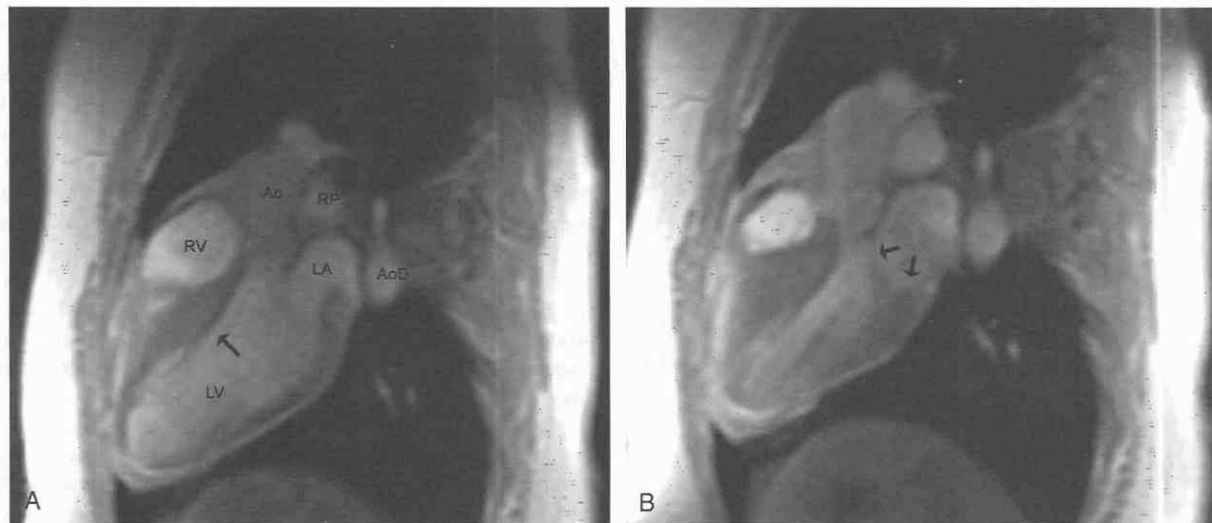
MR image obtained from a 17-year-old girl with hypertrophic obstructive cardiomyopathy. *A*, End-diastolic (ED) oblique axial-gradient reversal acquisition shows near-normal left ventricular (LV) size. The superior interventricular septum (arrow) is slightly asymmetrical with respect to the remainder of the LV myocardium. The right ventricle (RV), ascending (Ao) and descending (AoD) aorta, left atrium (LA), and right pulmonary artery (RP) are labeled. *B*, End-systolic (ES) image shows a dramatic difference in septal thickening, causing narrowing of the subvalvular left ventricular region. The mitral leaflets (arrows) are closed, and there is no mitral regurgitation.
